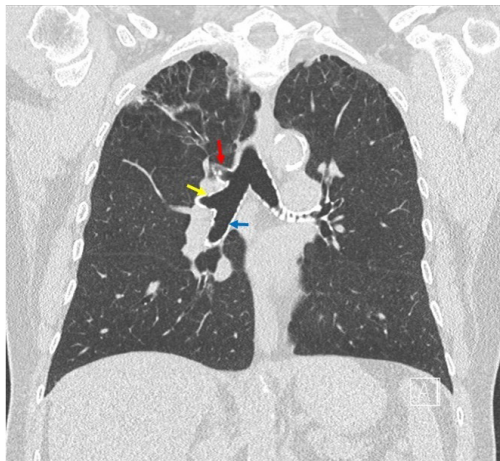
Chest computed tomography with two coronal sections demonstrating the presence of an aberrant apical right upper lobe bronchus (red arrow) with a second right upper lobe bronchus (yellow arrow) and normal bronchus intermedius (blue arrow).
